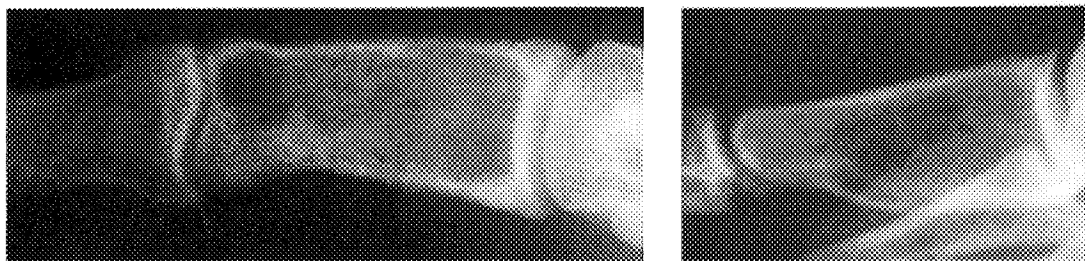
Left, AP and right, lateral radiographs of the proximal phalanx of the great toe of a patient who had a benign aneurysmal bone cyst. Note the geographic type of bone destruction. The bone is expanded but the lesion is margined by cortical bone.
